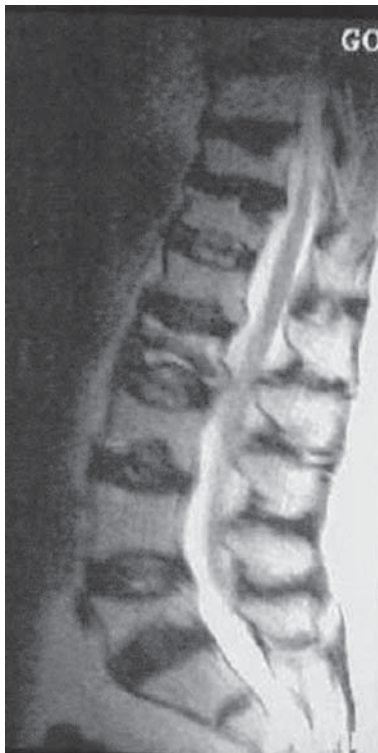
Continued* Three months later, (E) lateral spine radiograph, (F) CT sagittal reconstruction, (G) sagittal T1-weighted MR image, and (H) STIR sagittal image show progression of the L1 vertebral body fracture to vertebra plana. Note persistent edema signal in L1 and worsening local kyphotic deformity. T1-weighted and STIR sagittal MR images demonstrate new edema signal and within L3, representing a new compression fracture.
